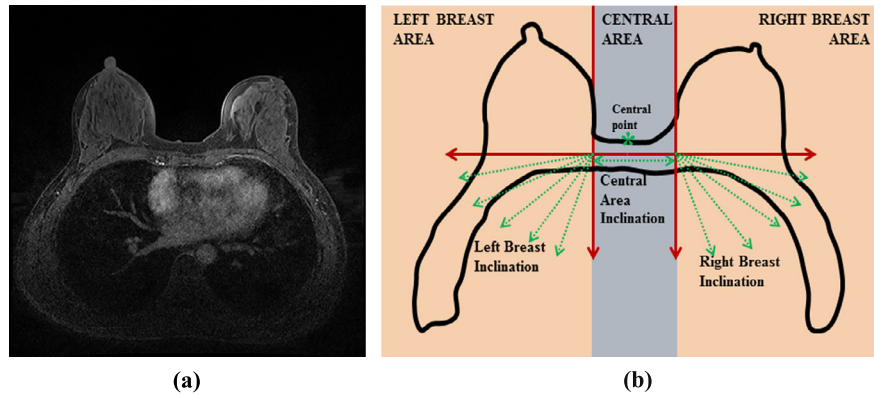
Identification of pectoral muscle area using a morphological operation. (a) MRI image. (b) A 2D image slice is divided into three different areas: 1) left 2) right and 3) central breast area. Each area is processed with a morphological operation in different orientation that develops a response image. These response images are merged to produce a single image.
